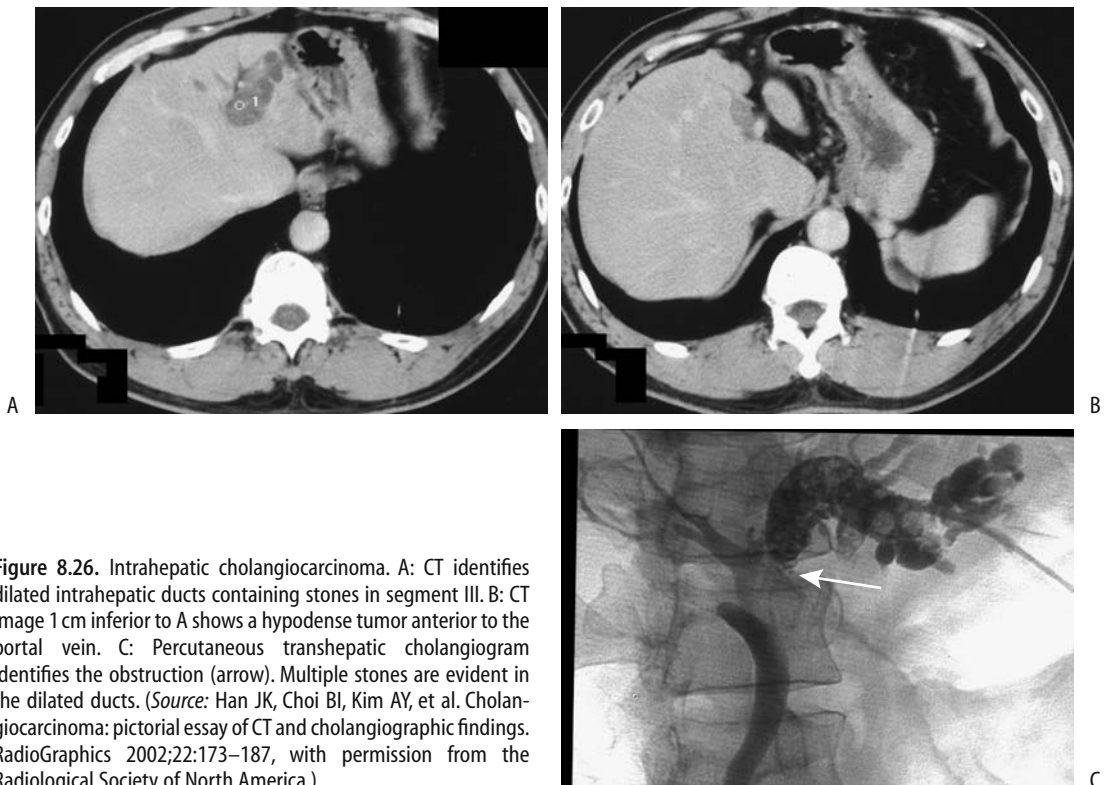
Intrahepatic cholangiocarcinoma. A: CT identifies dilated intrahepatic ducts containing stones in segment III. B: CT image 1 cm inferior to A shows a hypodense tumor anterior to the portal vein. C: Percutaneous transhepatic cholangiogram identifies the obstruction (arrow). Multiple stones are evident in the dilated ducts. (Source: Han JK, Choi BI, Kim AY, et al. Cholangiocarcinoma: pictorial essay of CT and cholangiographic findings. *RadioGraphics* 2002;22:173–187, with permission from the Radiological Society of North America.)
